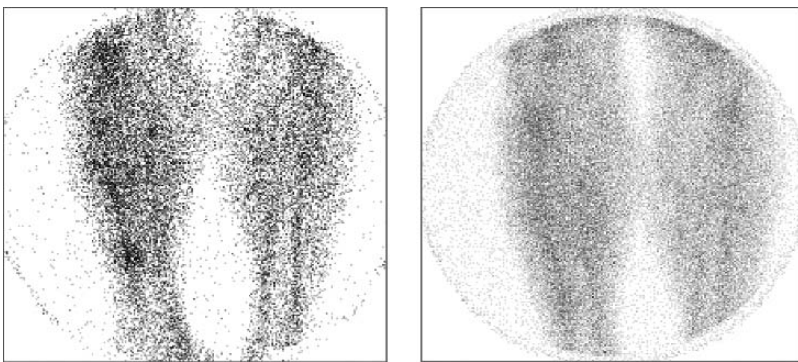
A truly positive ^{99m}Tc -HYNIC-PEG-liposome scintigram (*left*) and a falsely negative ^{111}In -labeled polyclonal IgG scintigram (*right*) of a patient with painful swelling and redness at the level of an old tibial fracture.
